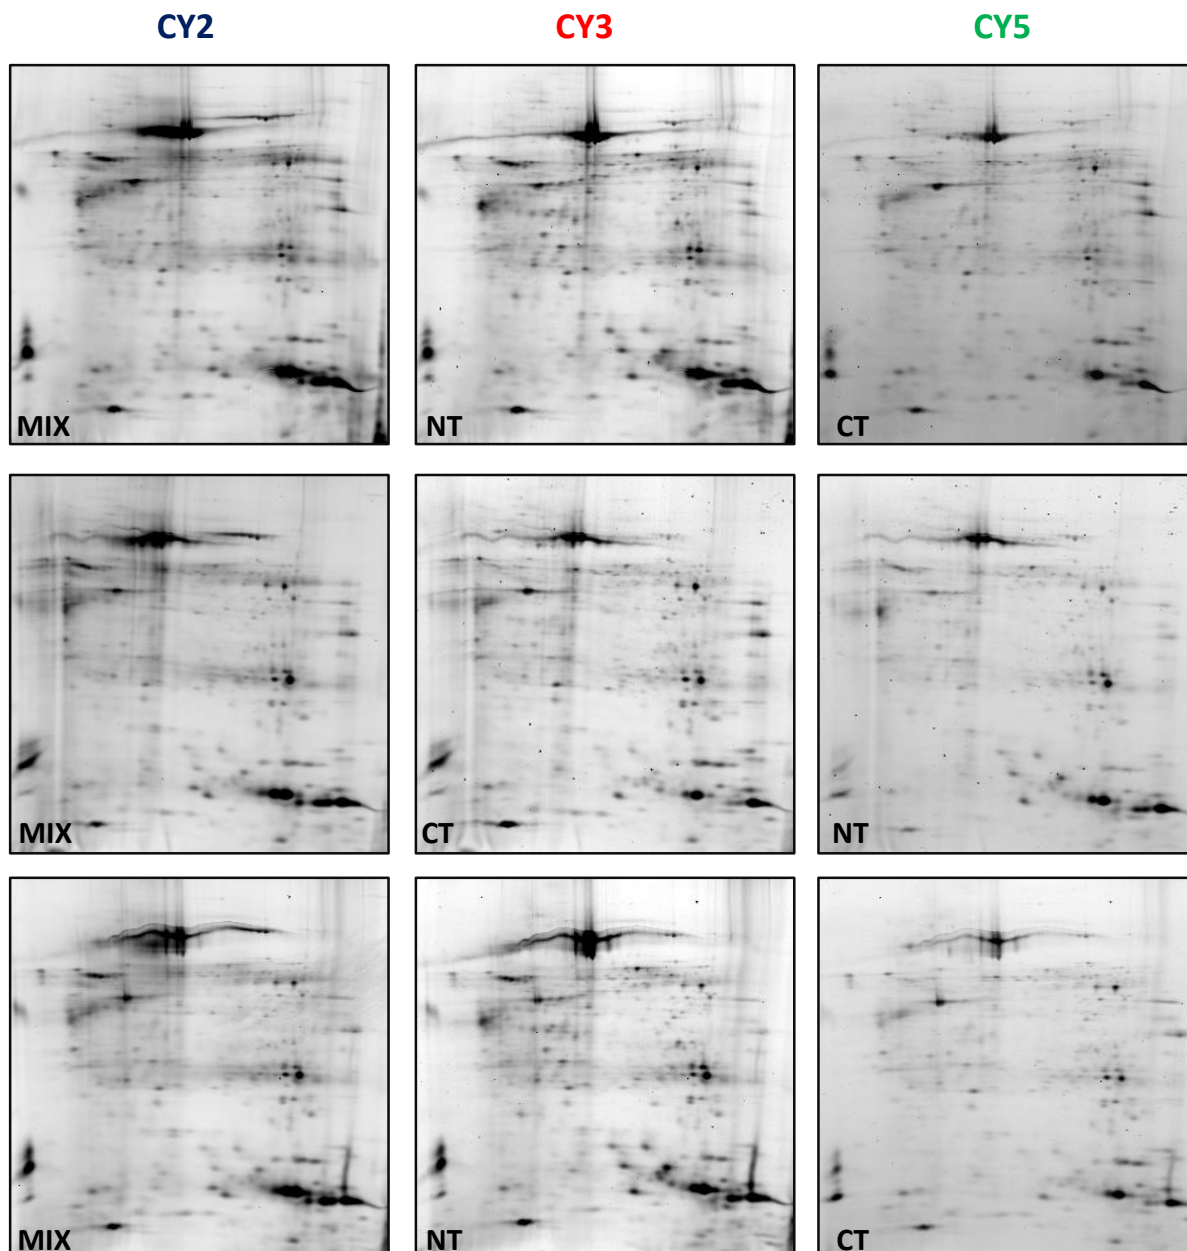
Panel showing the miniatures of the 2D-DIGE maps from NT and CT pools. Equal amounts of Cy2 (standard with equally mixed samples), Cy3 and Cy5 labeled samples were mixed and then separated on analytical 2D-DIGE.
